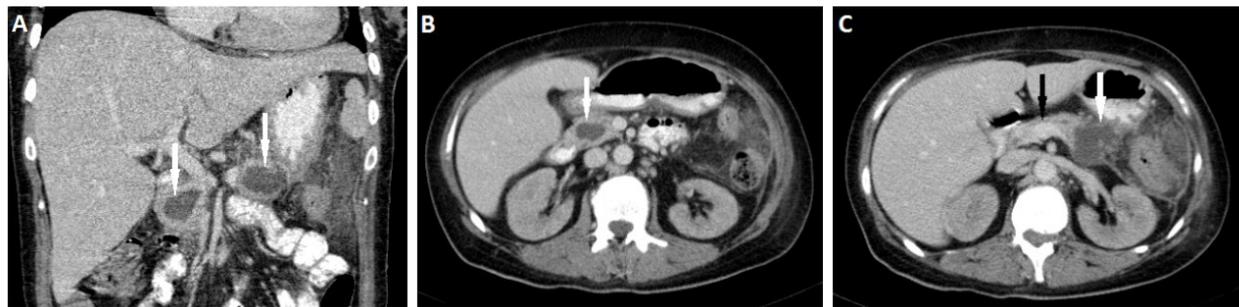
Computed tomography scans (A), (B), (C) show enlarged pancreas with irregular echogenicity and fluid collection (white arrows), (C) scan shows slightly dilated pancreatic duct (black arrow).
